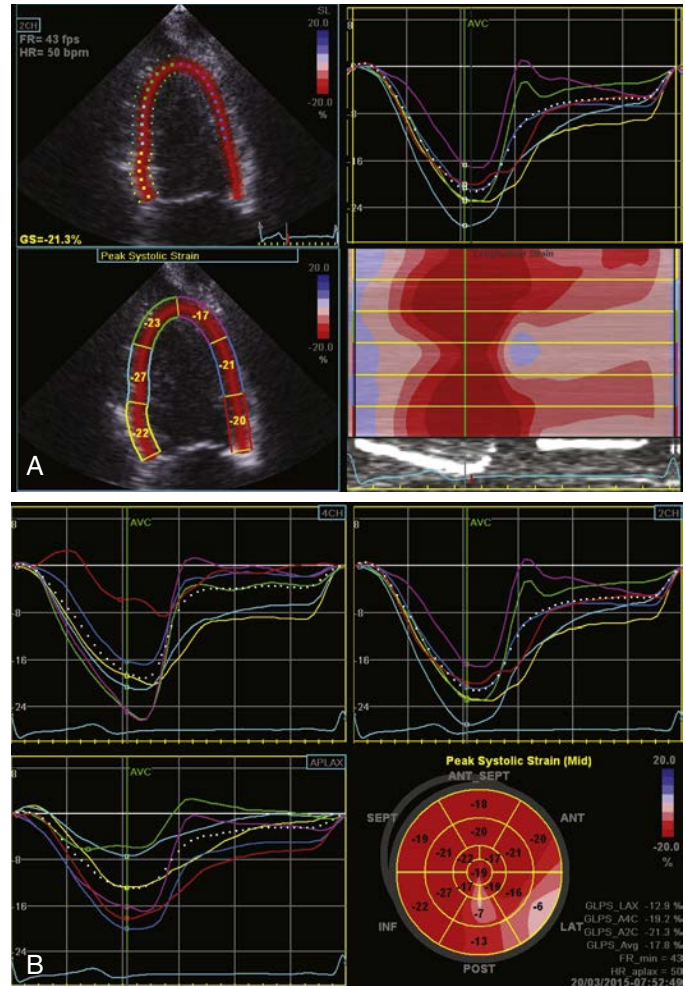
Assessment of myocardial mechanics using speckle-tracking echocardiography (SPE) techniques. (A) Normal peak longitudinal strain measured by SPE, two-dimensional strain (GE Healthcare, Milwaukee, Wisc.); the tracking and parametric images results are on the left and the results curves in the upper right panel. (B) Peak longitudinal strain measured by SPE, two-dimensional strain, from the apical four-chamber (4CH, upper left panel), two-chamber (2CH, upper right panel), and three-chamber (lower left panel) views, with bull's-eye representation of the midwall peak systolic strain (lower right panel). The dotted white lines show a reduced global longitudinal strain (GLPS) averaged from the inferoseptal (red line, 4CH) and inferolateral (yellow, blue, and green curves, APLAX) walls (global strain = -12.9% in LAX). The bull's-eye demonstrates RWMMAs of the lateral and posterior walls (light pink). APLAX, Apical long-axis view; AVC, aortic valve closure (for event timing); bpm, beats/min; FR, frame rate; HR, heart rate; RWMMAs, regional wall motion abnormalities.
